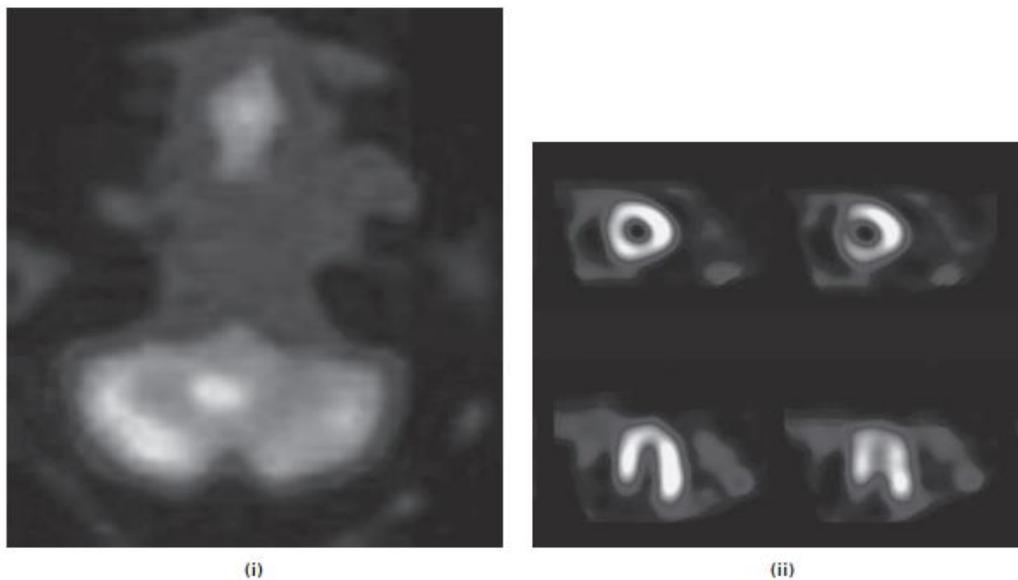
SPECT images showing (i) a brain tumor (in white), using ^{99m}Tc -GH , and (ii) thinning of the cardiac wall (reduced intensity), using ^{99m}Tc -sestamibi [11].
